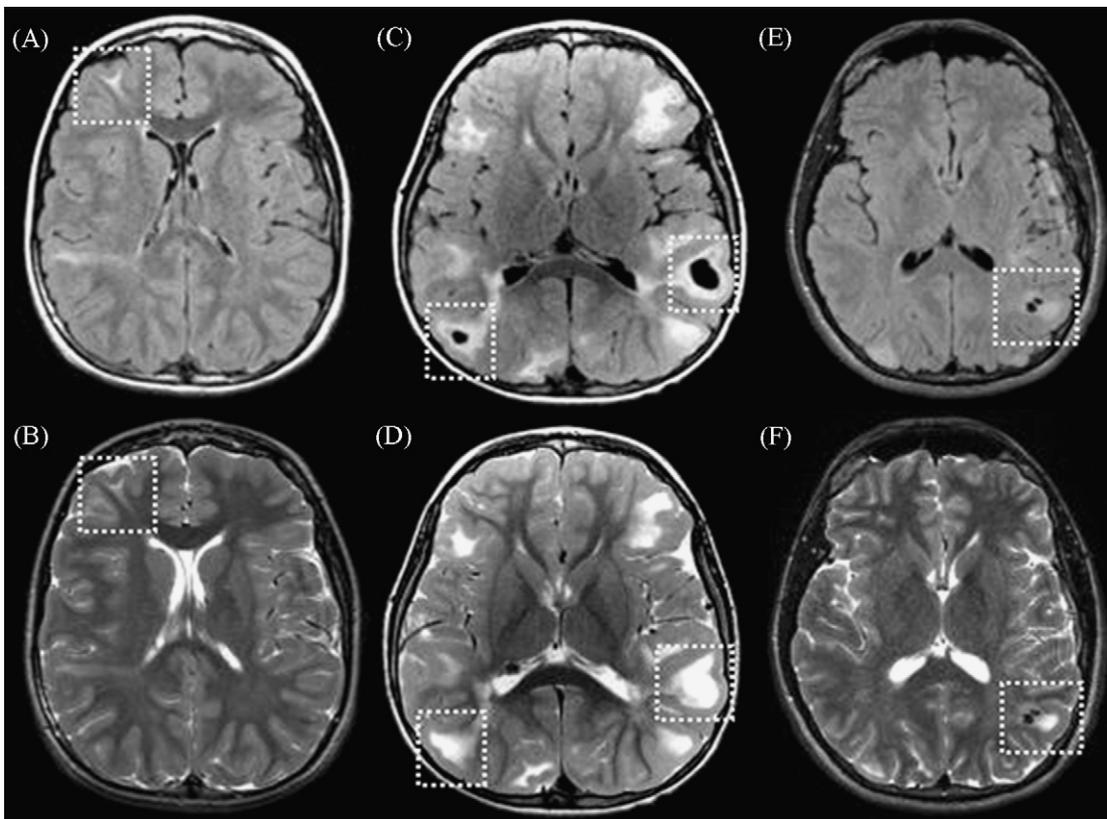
Axial MRIs showing in dotted boxes a cortical tuber on (A) FLAIR, and (B) T2 FSE sequences; cyst-like tubers on (C) FLAIR, and (D) T2 FSE images; and a calcified tuber on (C) FLAIR, and (D) T2 FSE sequences.
